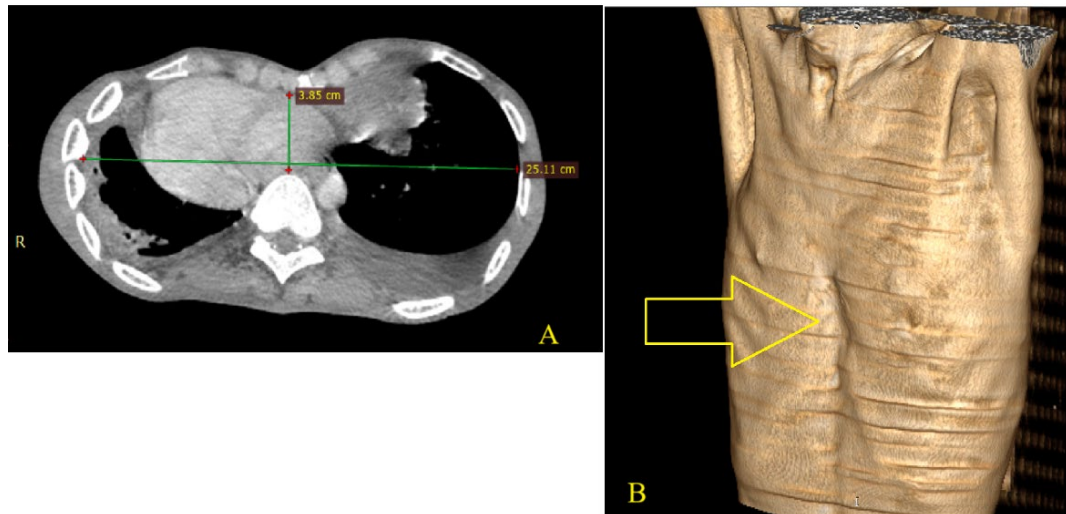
Chest CT scan. (A) Parenchymal window showing a severe Haller index; (B) Three-dimensional volume reconstruction demonstrating the pectus excavatum deformity.
